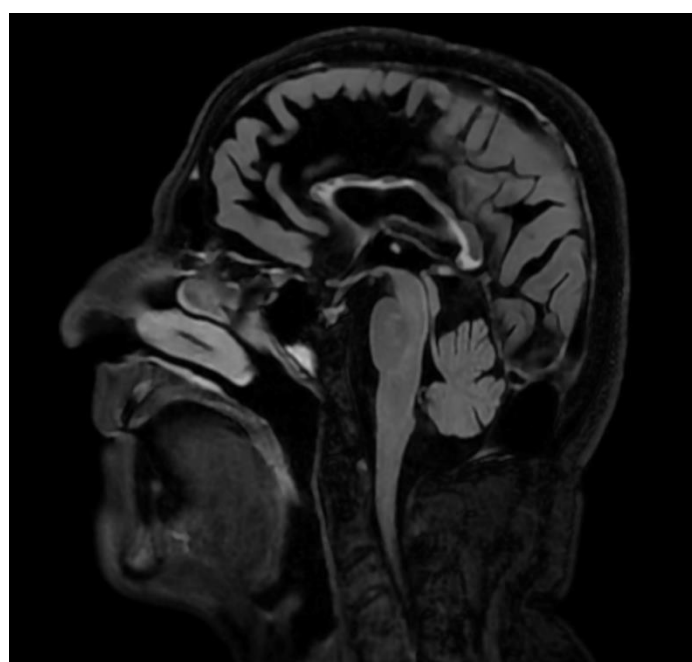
MRI image FLAIR sequence sagittal section shows hyperintense signal and atrophy of corpus callosum
